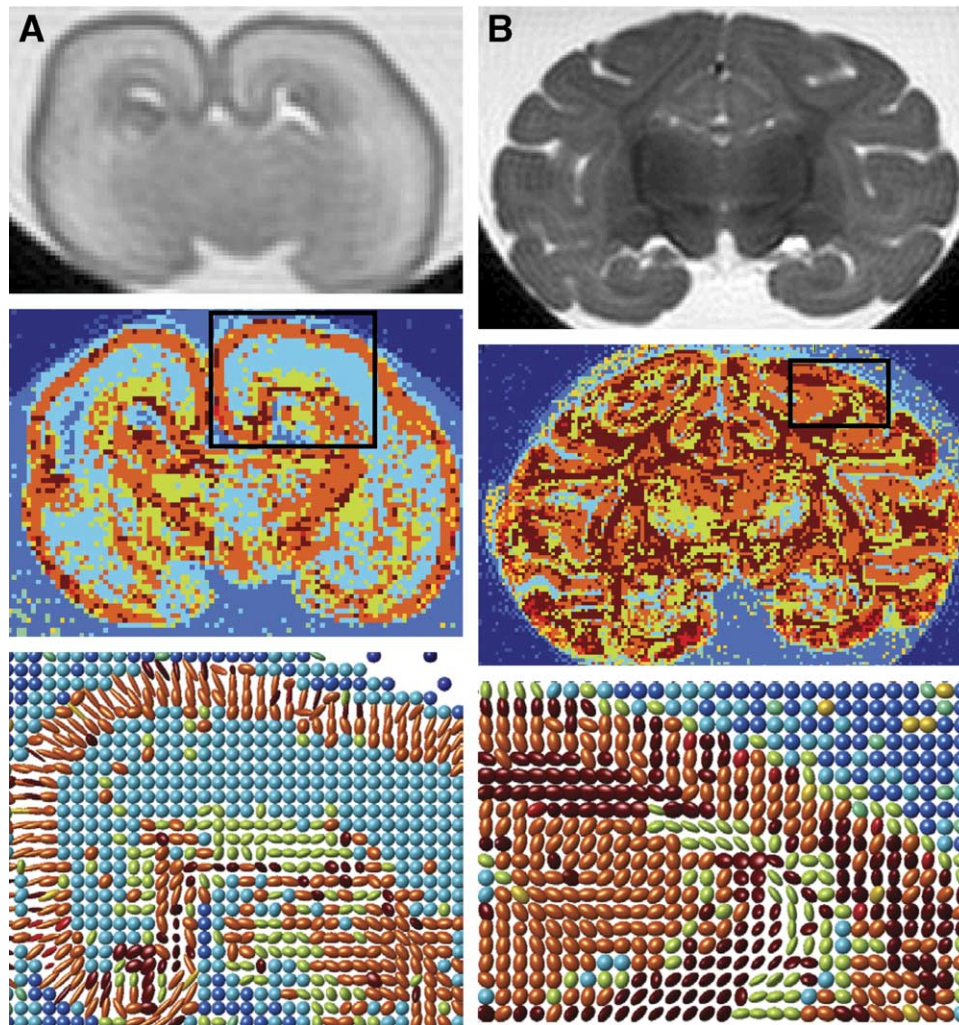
Images from (A) premature (90 days) and (B) term (185 days gestation) brains. T2-weighted images are shown in the top row for reference. The middle row shows the corresponding color-coded model selection maps. The ellipsoid maps in the bottom row are taken from the boxes shown in the model selection maps. See text for details.
